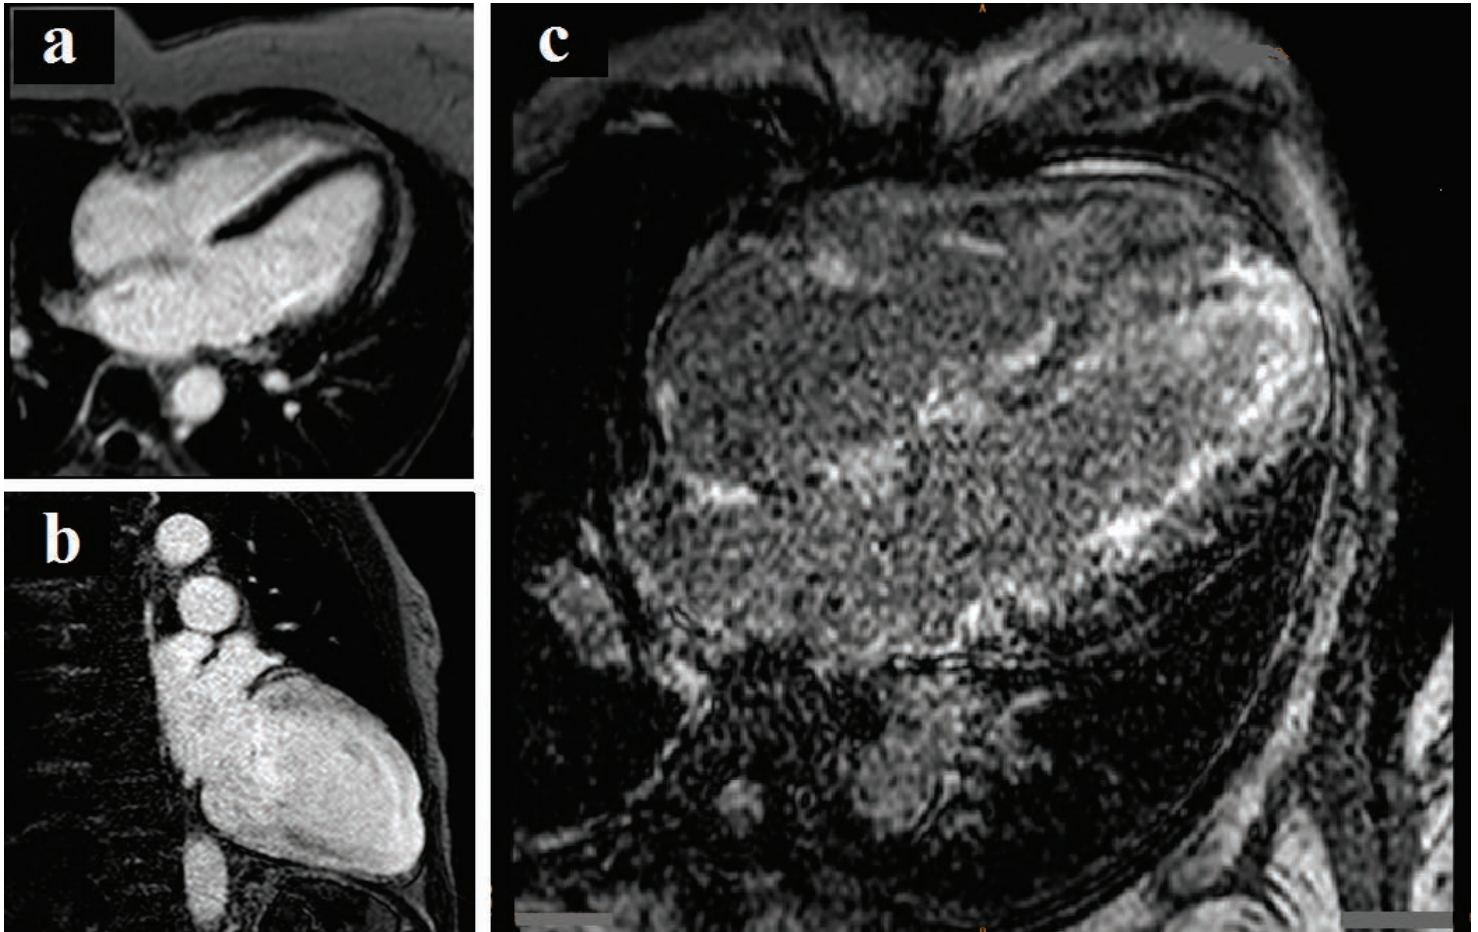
Magnetic resonance of the heart showing (a) an example of normal heart with “nulling” of myocardium; (b) gadolinium-enhanced cardiac magnetic resonance imaging showing inability to suppress (null) myocardial signal despite changing the inversion time; and (c) postgadolinium delayed enhancement image (4-chamber view) showing diffuse heterogeneous enhancement
